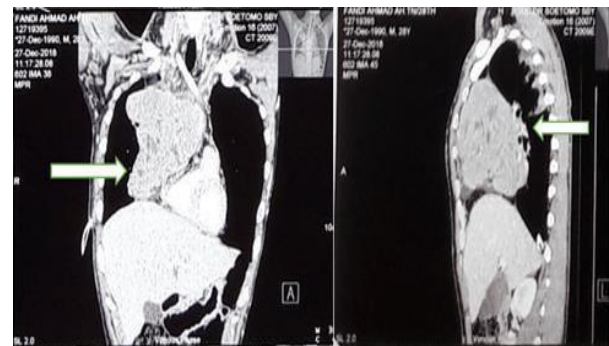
Chest CT-scan with contrast
